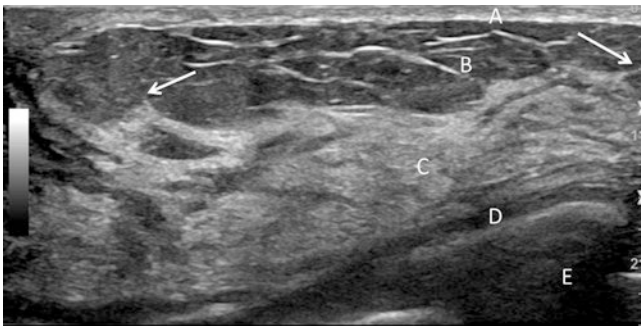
Normal ultrasound breast anatomy. From superficial to deep: A, skin; B, pre-mammary subcutaneous fat; C, mammary zone containing fibroglandular tissue; D, retro-mammary fat; and E, chest wall. Arrows show Cooper's ligaments anteriorly at the junction of the pre-mammary and mammary zones
